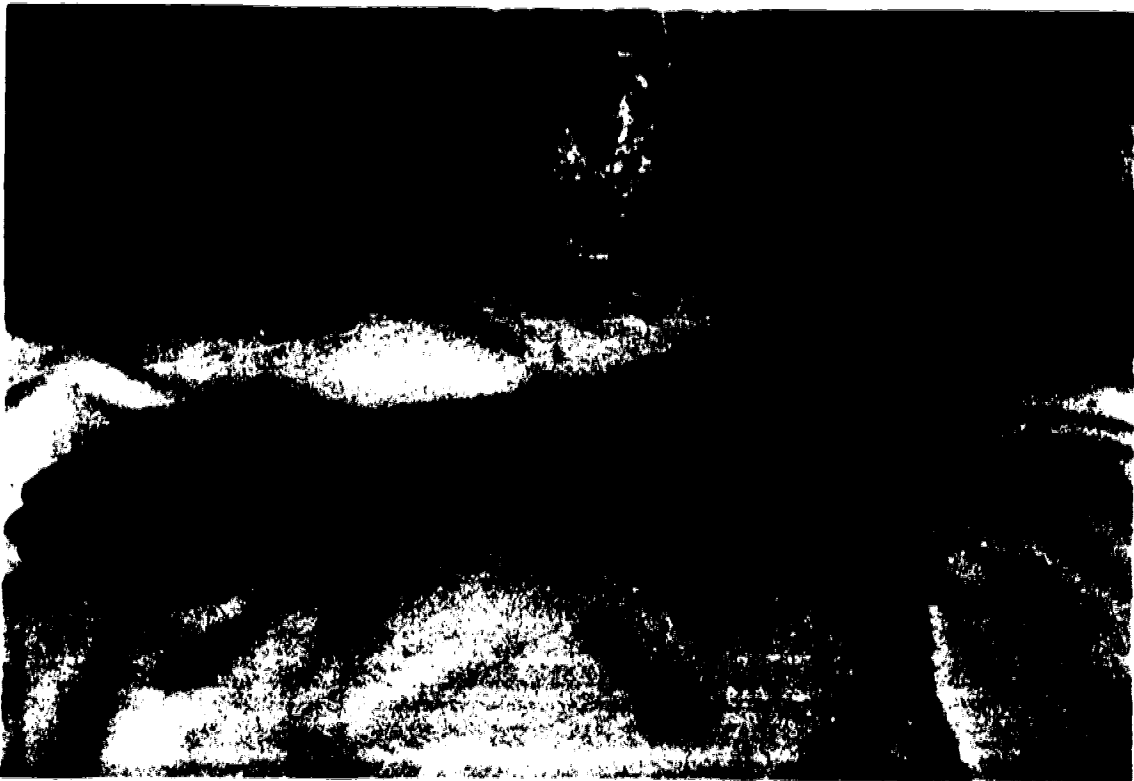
Method of application of the ultrasound treatment.
